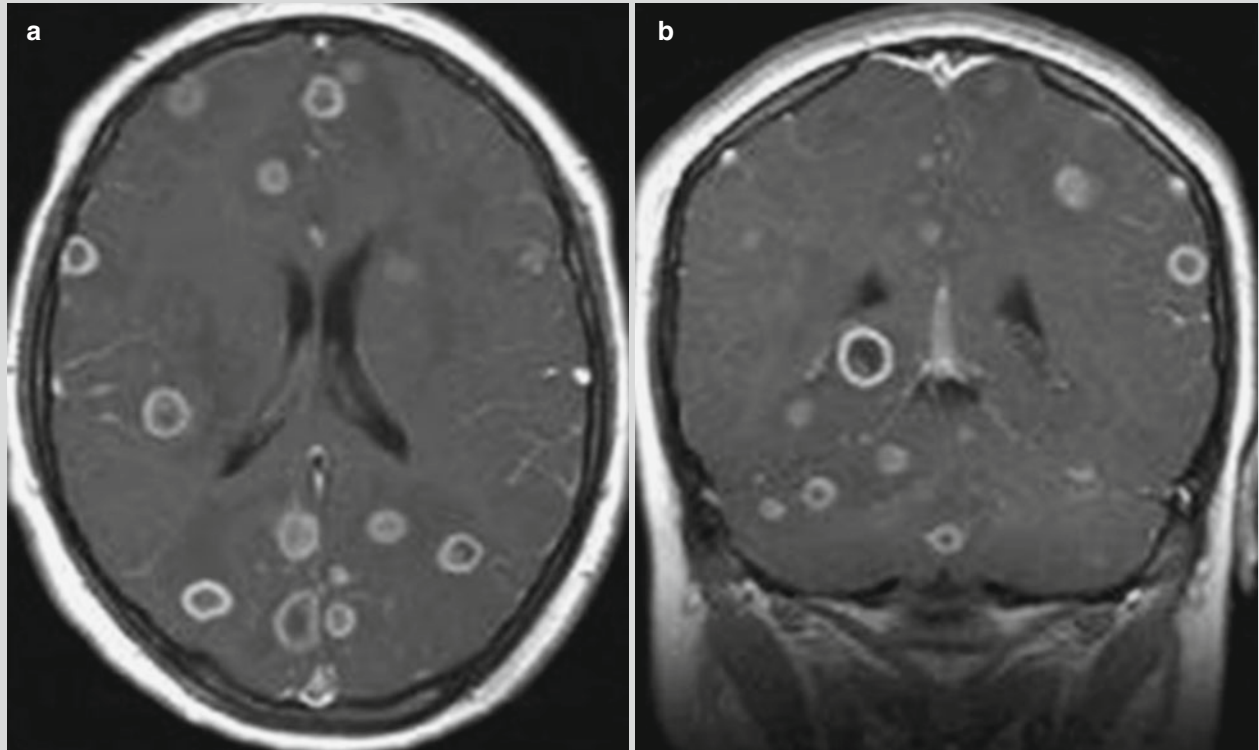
Amoebic brain abscess. (a, b) Contrast T1WI of MRI demonstrates multiple lesions with ring-shaped enhancement in supratentorial and subtentorial brain parenchyma and involved bilateral frontal lobes, temporal lobes, and occipital lobes. Large
